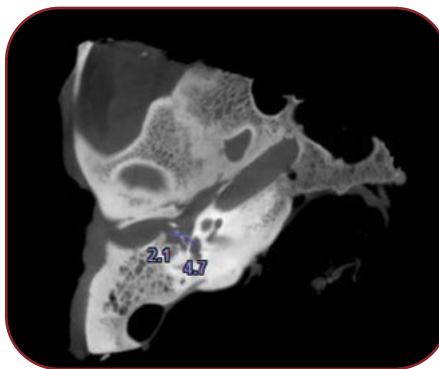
Distance between the stapes and round window and incudostapedial joint thickness on a low-resolution cone-beam computed tomography (LR-CBCT) image
